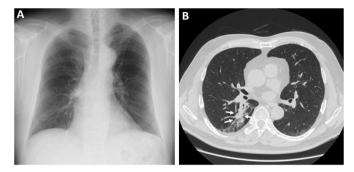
Findings on chest radiography and computed tomography (CT) on admission. A. Chest radiography showed infiltrative shadow on the right middle field. B. Chest CT disclosed gloved finger sign along broncho-vascular bundles with the formation of mucoid impaction in superior segment of right lower lobe (white arrow).
